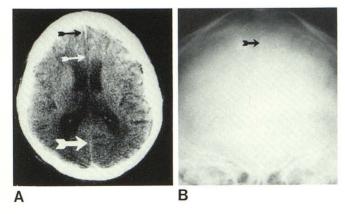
Normal uncalcified falx. A, Retrocallosal (*large white arrow*) and precallosal (*black arrow*) segments of falx are visualized in patient who subsequently died and in whom postmortem examination demonstrated no evidence of falx calcification. Thus, falx visualization is due to intrinsic density difference between this structure and the surrounding brain, rather than calcification. B, Frontal skull radiograph. Visualization of uncalcified falx as linear midline hyperdensity.
